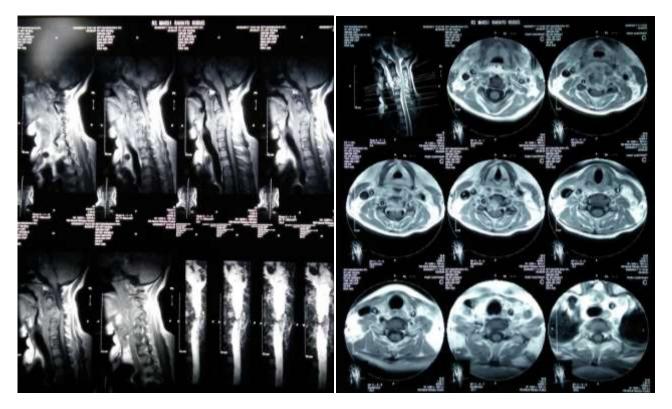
Cervical MRI in sagittal and axial windows
